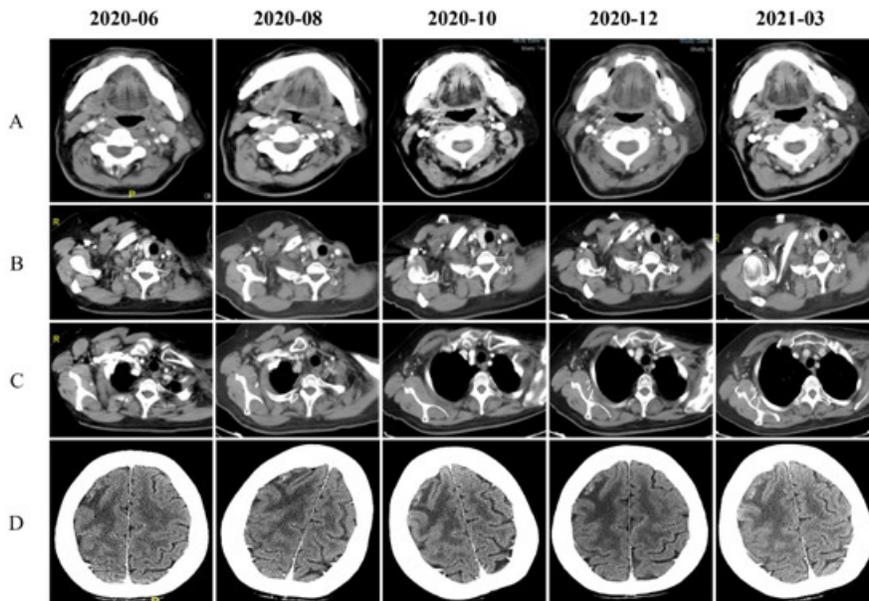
Enhanced CT scan before and after the treatment of anlotinib and tislelizumab. The left Cervical lymph node (A), the right supraclavicular lymph node (B), the right axillary lymph node (C), and the metastatic brain lesion (D) all shrank.
